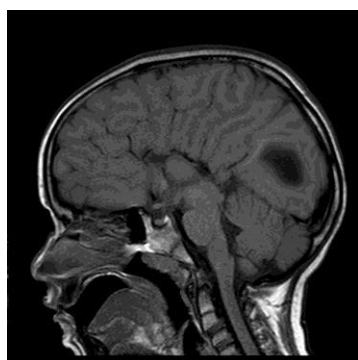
MRI brain that showed hypoplasia of corpus callosum.
